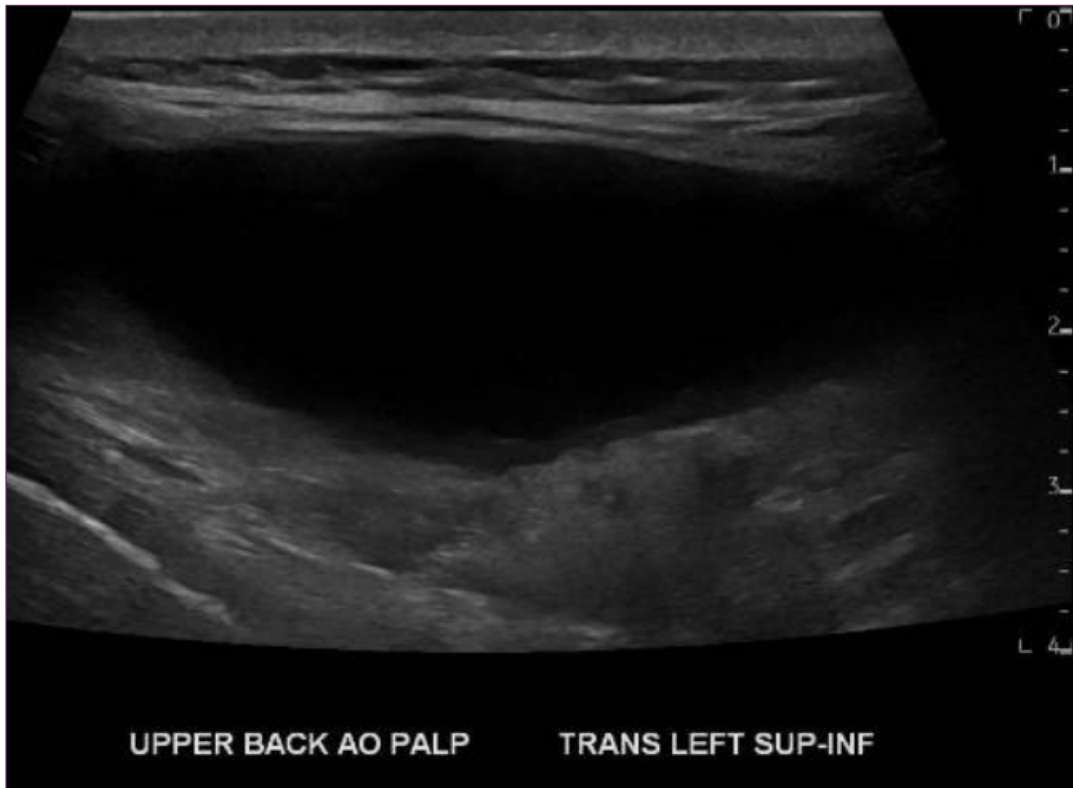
Ultrasound imaging demonstrates a large anechoic fluid collection contained between subcutaneous soft tissue and musculature of the bilateral upper back without evidence of loculation.
